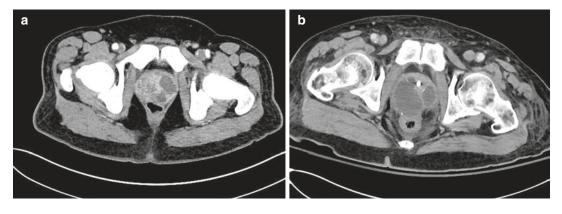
CT imaging showing large, multifocal prostatic abscesses in two patients (a and b), both treated with transurethral unroofing
